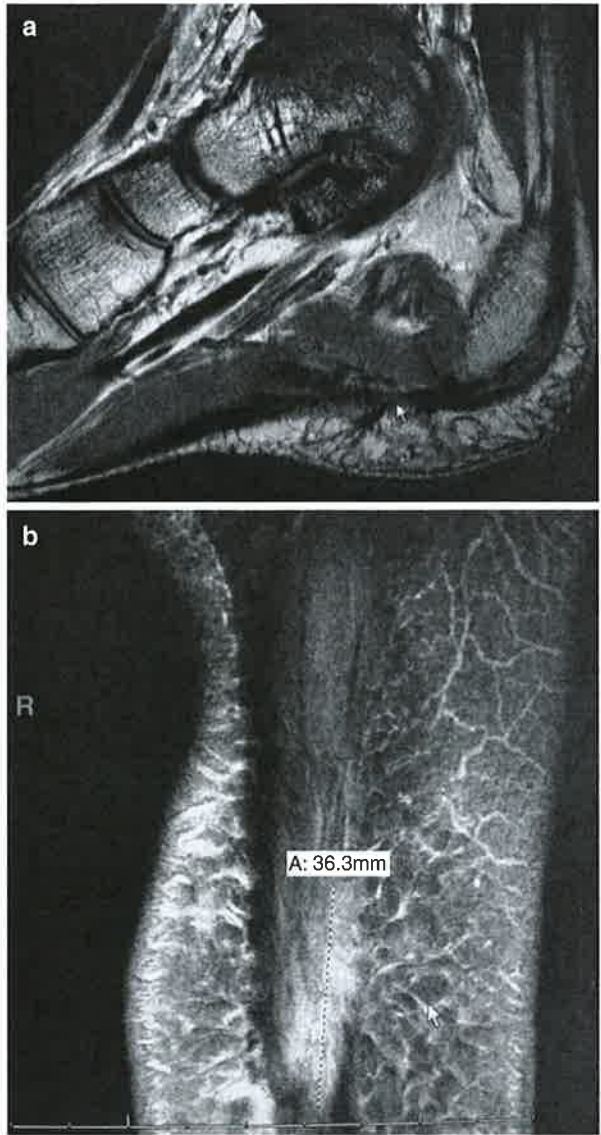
MRI showing thickened plantar fascia
